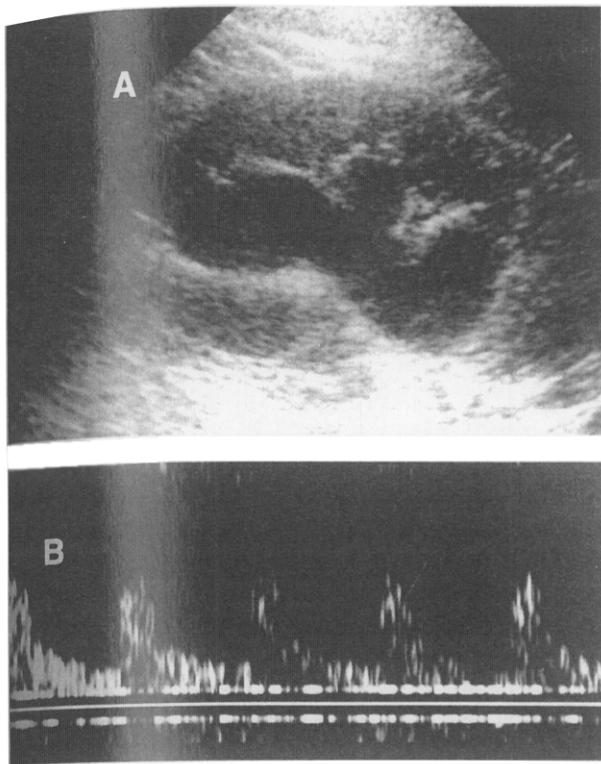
Case 2. (A) Left renal ultrasound showing moderate dilatation of collecting systems, and (B) normal Doppler US of left kidney, with normal resistive index of 0.66.
